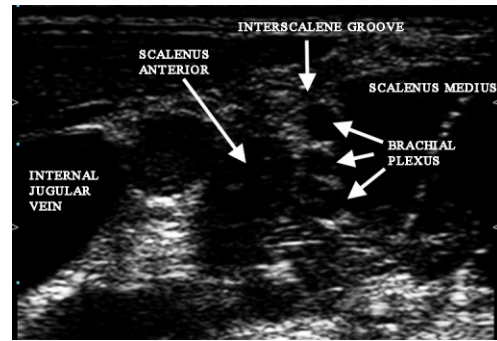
Sonogram of mid level interscalene groove prior to block
